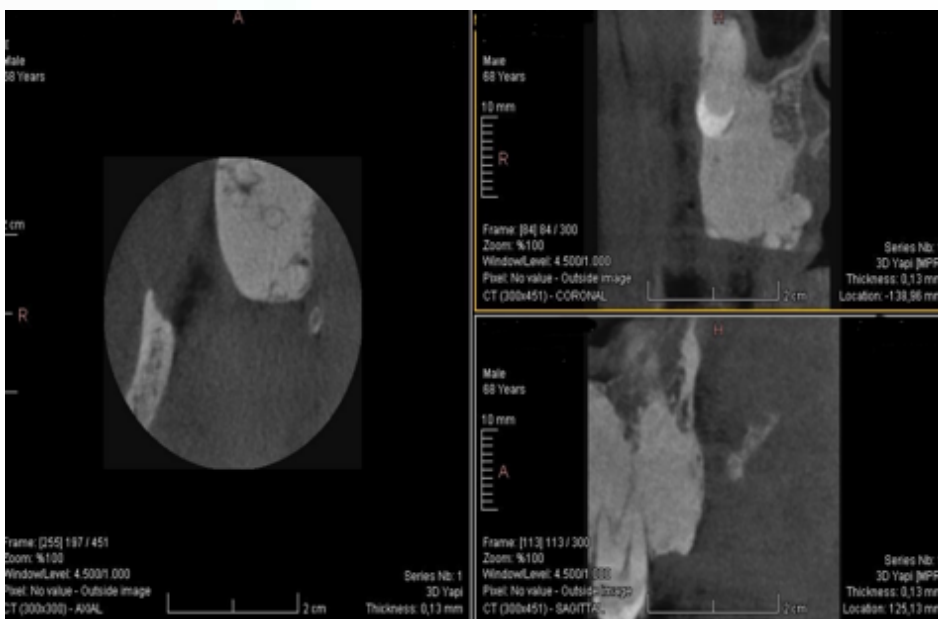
CBCT image of the patient
